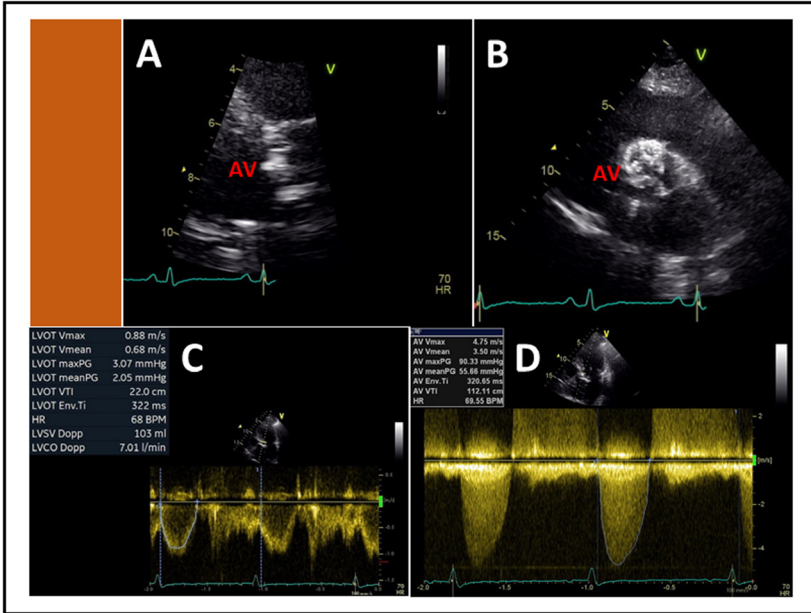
Echocardiographic images of a male patient in his late 80s, with aortic stenosis (AS) presented with a grade 4/6 systolic murmur on aortic position and a weakened second heart sound. There was no obvious audible diastolic murmur. Parasternal long-axis (A) and short-axis (B) show densely calcified aortic valve (AV). C shows stroke volume of 103 ml consistent with a mild aortic regurgitation. D displays peak aortic jet velocity of 4.7 m/s and mean pressure gradient of 56 mmHg, consistent with severe AS. Left ventricular ejection fraction was 55%.
